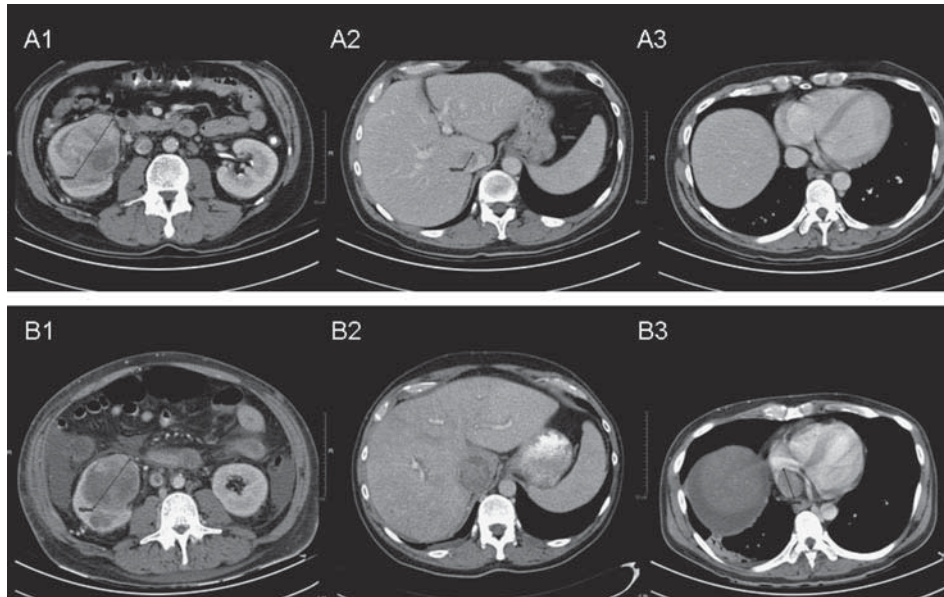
CT scans of the first patient at baseline (A) and after (B) one cycle of sunitinib. A1 and B1: The primary tumour has decreased in size. A 2-3 and B 2-3: The caval vein thrombosis has increased in size (A2 and B2) and extends from infrahepatic (A2) towards the right atrium (B3). Note the absence of the thrombus in the right atrium before treatment (A3).
